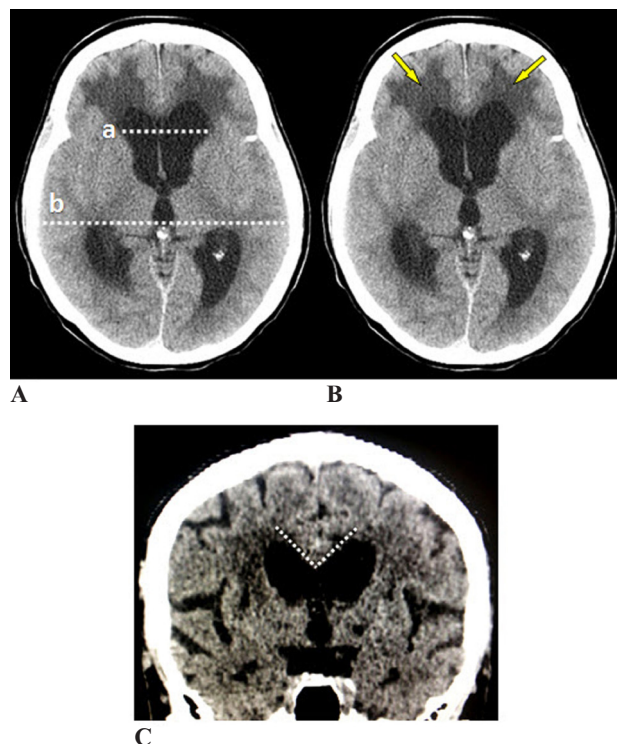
(A) The Evans ratio is the proportion between the maximal ventricular width (a) and the maximal biparietal distance from one side of the inner table of the skull to the other (b). (B) Transependymal CSF resorption demonstrated as periventricular hypodensity (arrows) on cranial CT scan. (C) The callosal angle shows a sharp contour in NPH
